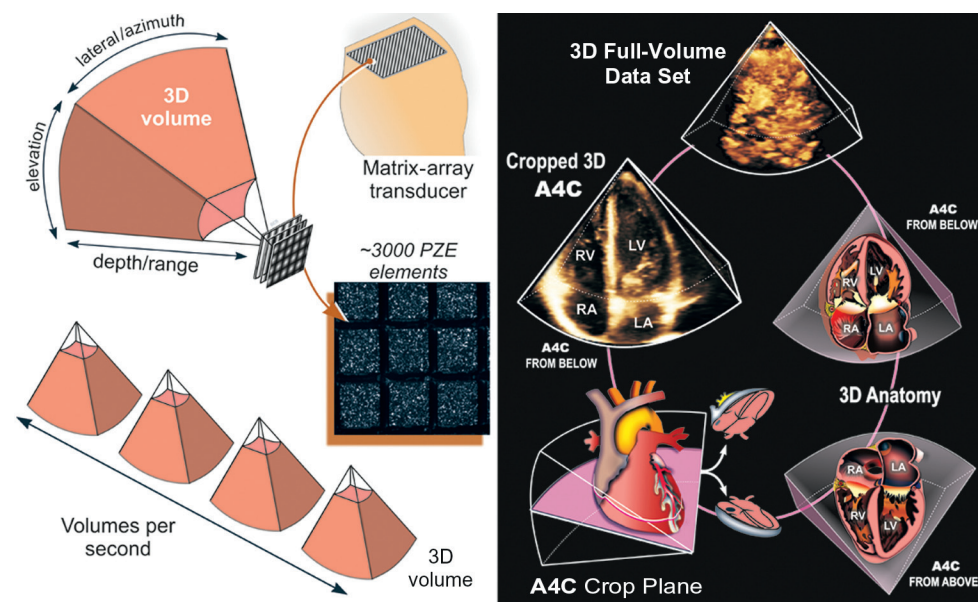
Three-dimensional (3D) echocardiography using a matrix-array transducer. A waffle-like matrix array (left panel) is used to obtain pyramidal “volumes” for real-time 3D data sets that can be cropped (right panel) and rendered in three dimensions. Alternatively, two-dimensional planes can be “cut” through any part of the 3D data set. A4C = apical four chamber. (Modified from Bulwer BE, Rivero JM [eds]: *Echocardiography Pocket Guide: The Transthoracic Examination*. Burlington, Mass, Jones & Bartlett Learning, 2011, 2013, p 208. Reprinted with permission.)
